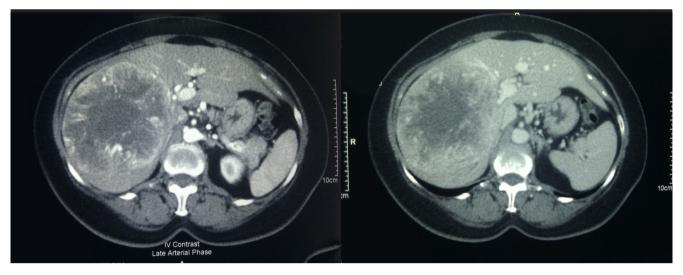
CT scan abdomen of case 1 showing huge peripherally enhancing tumour in the right lobe of liver during late arterial phase with washout on portovenous phase.
